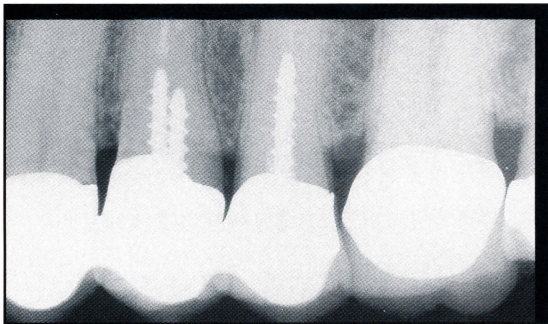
Radiograph following 2 months of forced eruption. Note the modified position of the first premolar tooth.
